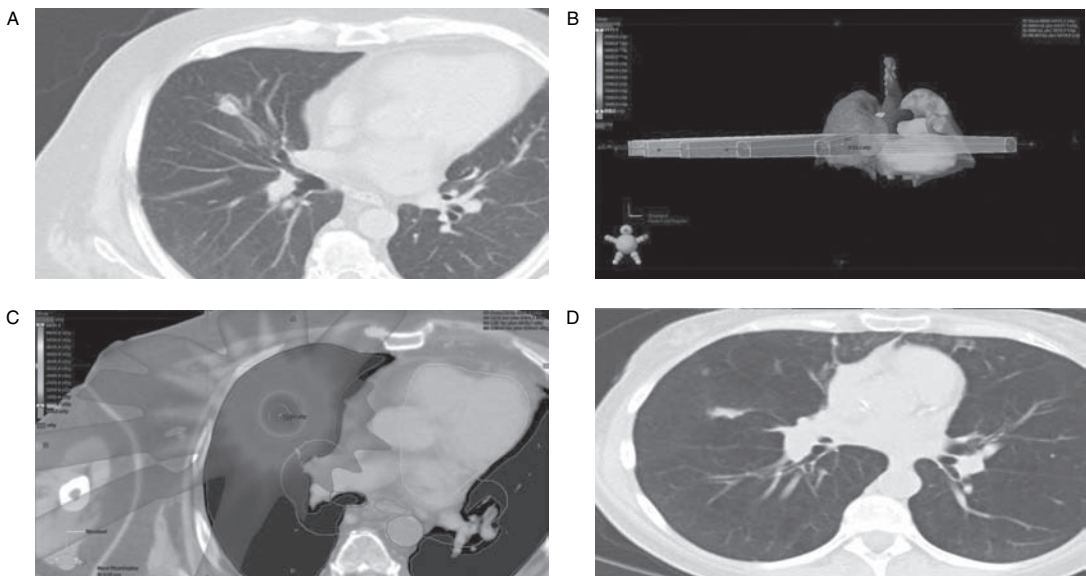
Representative images from the use of stereotactic body radiotherapy to definitively treat a peripherally located primary non–small cell lung cancer, including (A) the pretherapy tumor on axial computed tomography (CT) image, (B) representative beam arrangement from treatment plan, (C) representative dose distribution based on a prescription dose of 54 Gy in three fractions, and (D) 15-month follow-up axial CT image.
